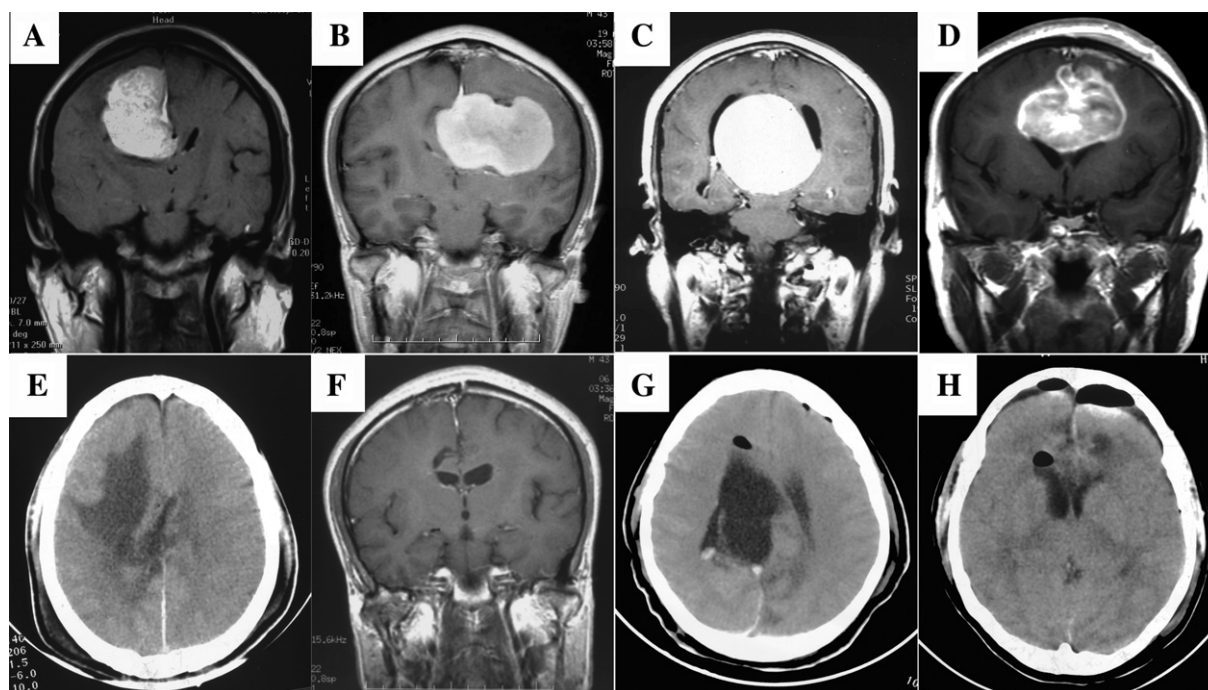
(A–D) Preoperative coronal, contrast-enhanced T1-weighted MRI revealing four types of falcine meningioma (FM): (A) Type I, (B) Type II, (C) Type IIIA, and (D) Type IIIB. (E–H) Postoperative axial CT scans (E, G, and H) and coronal contrast enhanced T1-weighted MRI (F) showing complete tumour resection (E, Type I; F, Type II; G, Type IIIA; H, Type IIIB).
